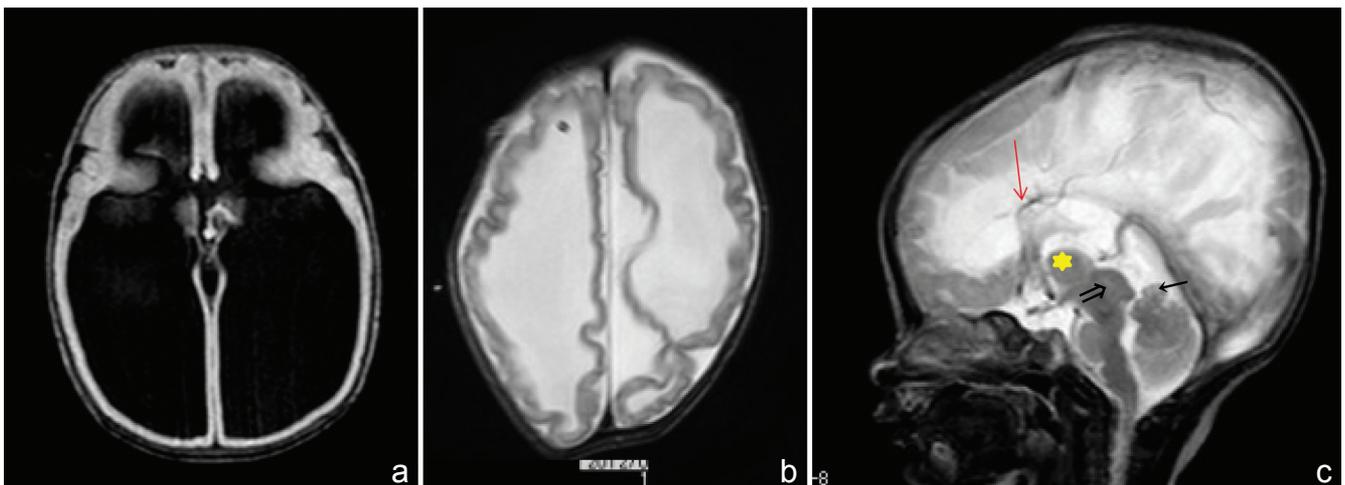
X-linked hydrocephalus with *L1* gene mutation. a: MRI (T₁) shows severe ventricular dilatation. b: MRI (T₂) after VP shunt shows rippled ventricular wall. c: MRI (T₂) shows an enlarged massa intermedia (☆) anterior vermian hypoplasia (←), and a large quadrigeminal plate (⇒), callosal dysplasia was observed (↓). MRI: magnetic resonance imaging, VP: ventriculoperitoneal.
